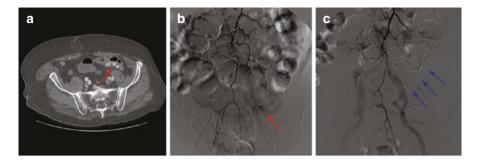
Bleeding and intervention in a patient with diverticulosis. (a) CTA demonstrating active extravasation of contrast in the sigmoid colon at a diverticulum (red arrow), indicative of active lower GI bleeding. (b) Digital subtraction angiography images demonstrating active extravasation of contrast (red arrow) from the sigmoid branch of the inferior mesenteric artery. (c) Digital subtraction angiography images demonstrating (absence of blush) after Gelfoam slurry embolization into the IMA (blue arrows)
